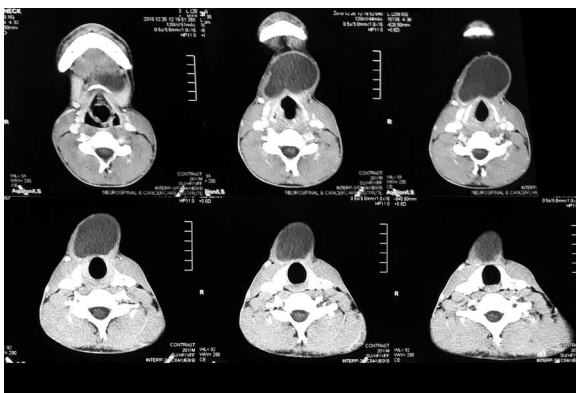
CT scan findings on coronal view
